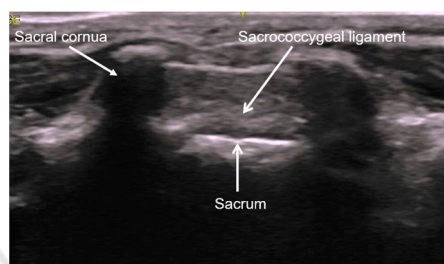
Ultrasound image of sacral hiatus.
